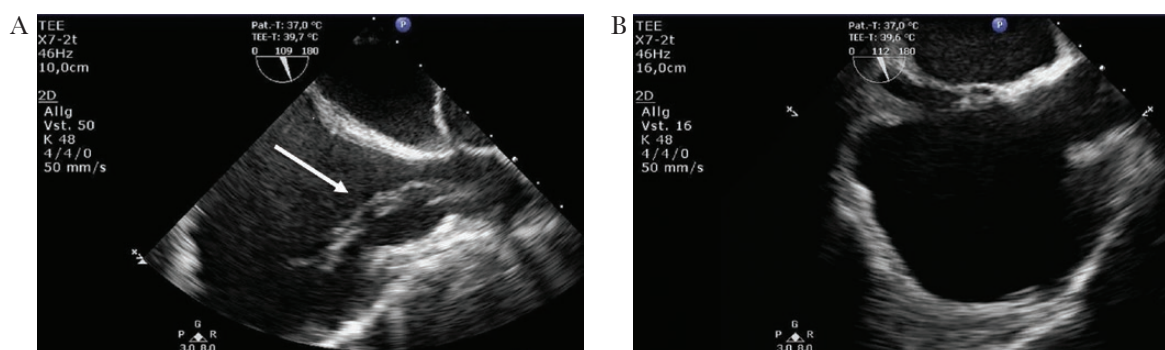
Transesophageal echocardiography (TEE) results. A, TEE revealing mobile vegetation from the right atrium to the superior vena cava. B, Control TEE with elimination of endocarditis vegetation.
